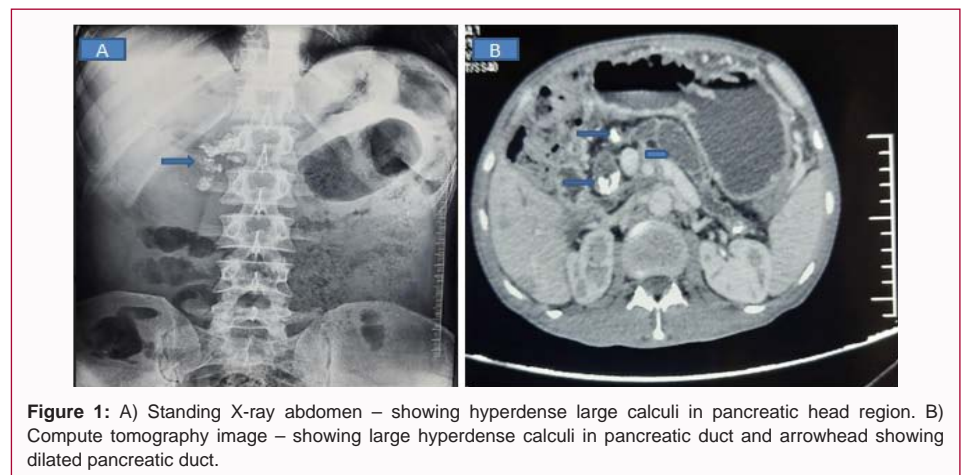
A) Standing X-ray abdomen – showing hyperdense large calculi in pancreatic head region. B) Compute tomography image – showing large hyperdense calculi in pancreatic duct and arrowhead showing dilated pancreatic duct.
